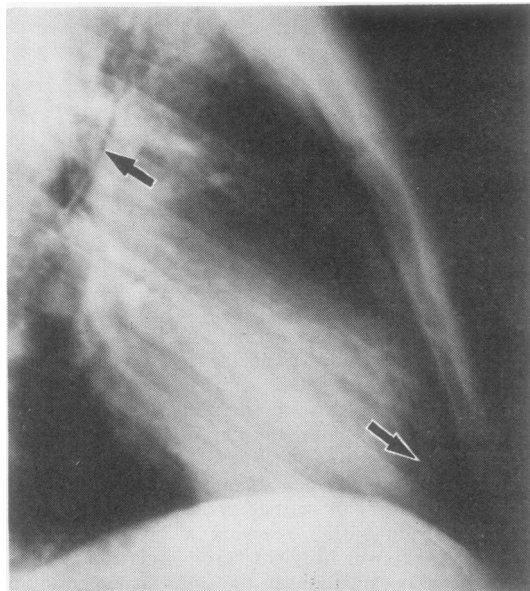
Lateral chest radiograph shows a rim of air along the edge of the pericardium consistent with pneumomediastinum.
